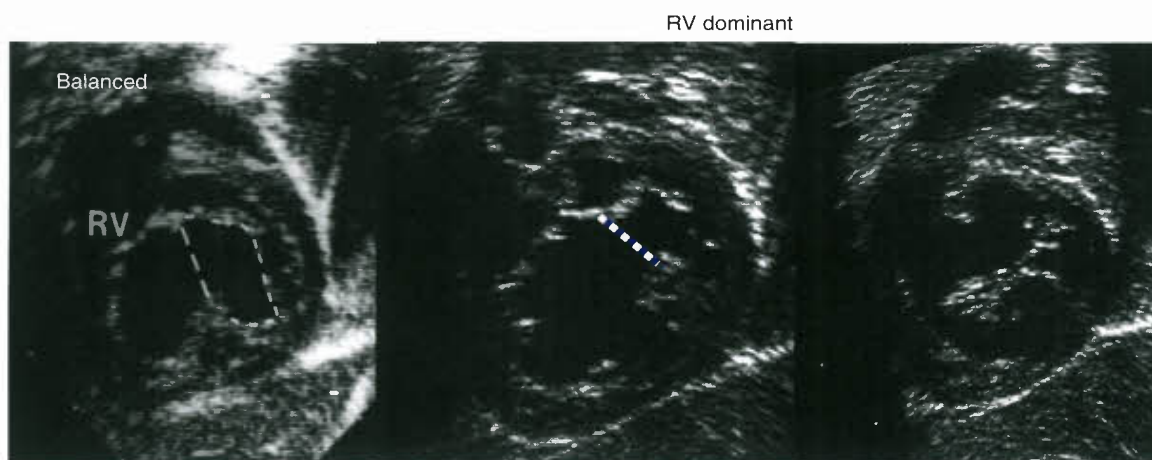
Echocardiographic assessment of ventricular dominance: Assessing unbalanced AVSDs using AV valve area measurements. Left panel: Diastolic frame from the subcostal sagittal plane demonstrating an en face view of the common AV valve. The planimetry demonstrates relative balance between the right and left portions of the common valve. Center panel: Diastolic frame demonstrating an RV-dominant unbalanced AVSD with relative dominance of the right portion of the common AV valve. Right panel: Companion systolic frame of an RV-dominant AVSD. (From Cohen M, Jacobs ML, Weinberg PM, et al. Morphometric analysis of unbalanced common atrioventricular canal using two-dimensional echocardiography. *J Am Coll Cardiol* 1996;28:1017, with permission.)
